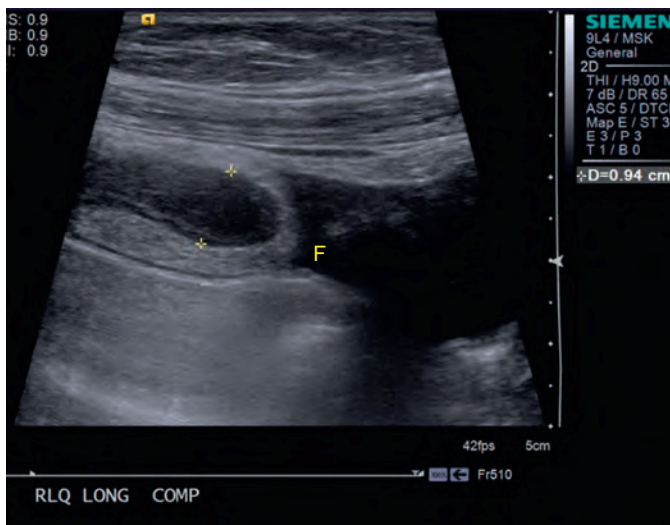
Ultrasound of appendicitis with periappendiceal fluid. A. Longitudinal imaging with graded compression in a 7-year-old girl demonstrates a dilated appendix with a diameter of 9 mm (cursors). Wall stratification is maintained, and periappendiceal fluid (F) is visualized.
